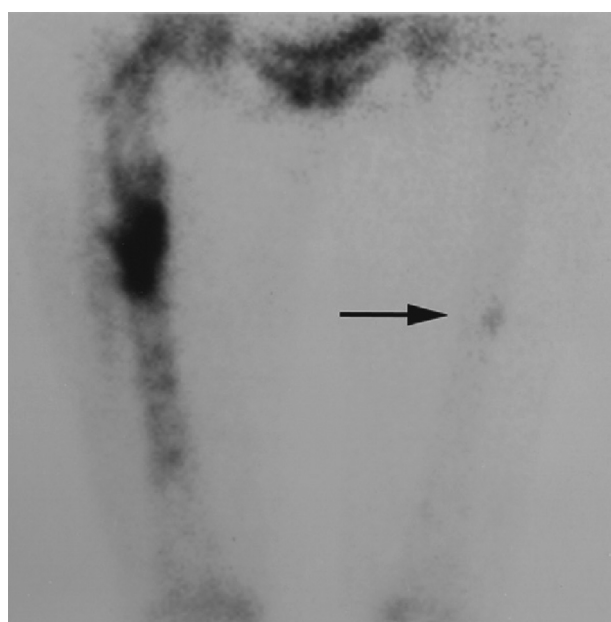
Bone scintigraphy of a patient presented on Figure 2. Status after subtrochanteric fracture fixation on the left, and increased uptake of marker on the right side
